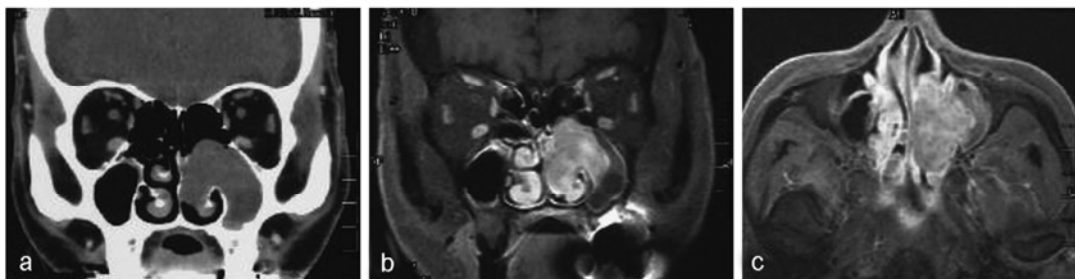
Diagnostic images of the tumor. (a) Enhanced axial CT shows a homogeneously enhancing mass that fills the posterior part of the left nasal cavity and the maxillary sinus. (b and c) Gd-enhanced axial and horizontal MRI show a prominent and inhomogeneously enhancing mass that originates in the medial wall of the left maxillary sinus.
